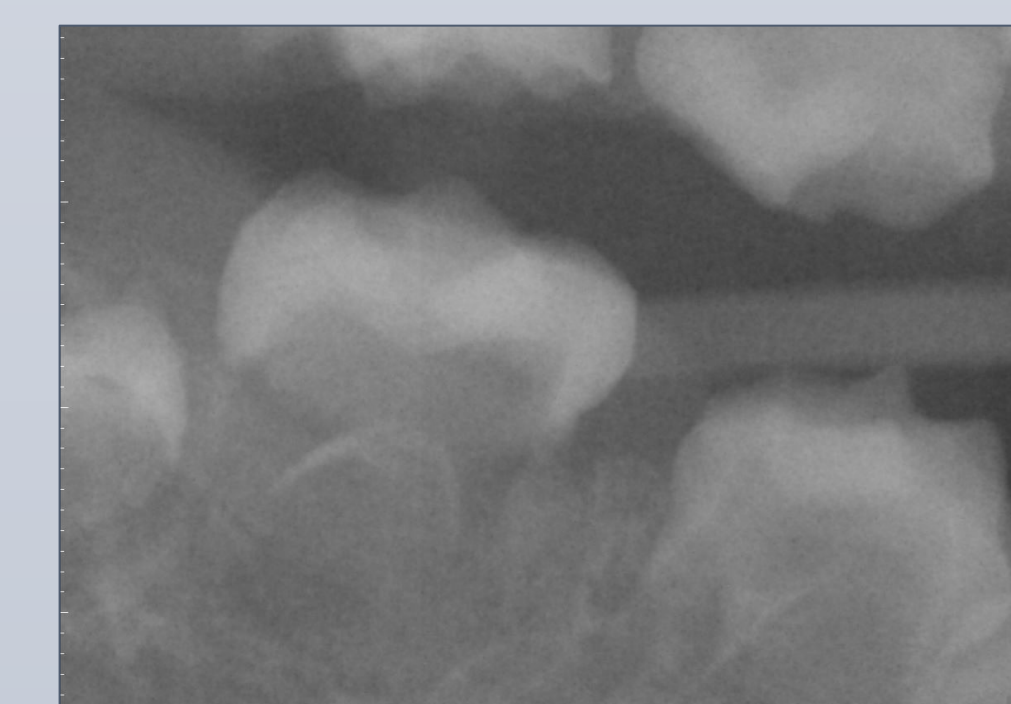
Right Bitewing 12/21/2016
